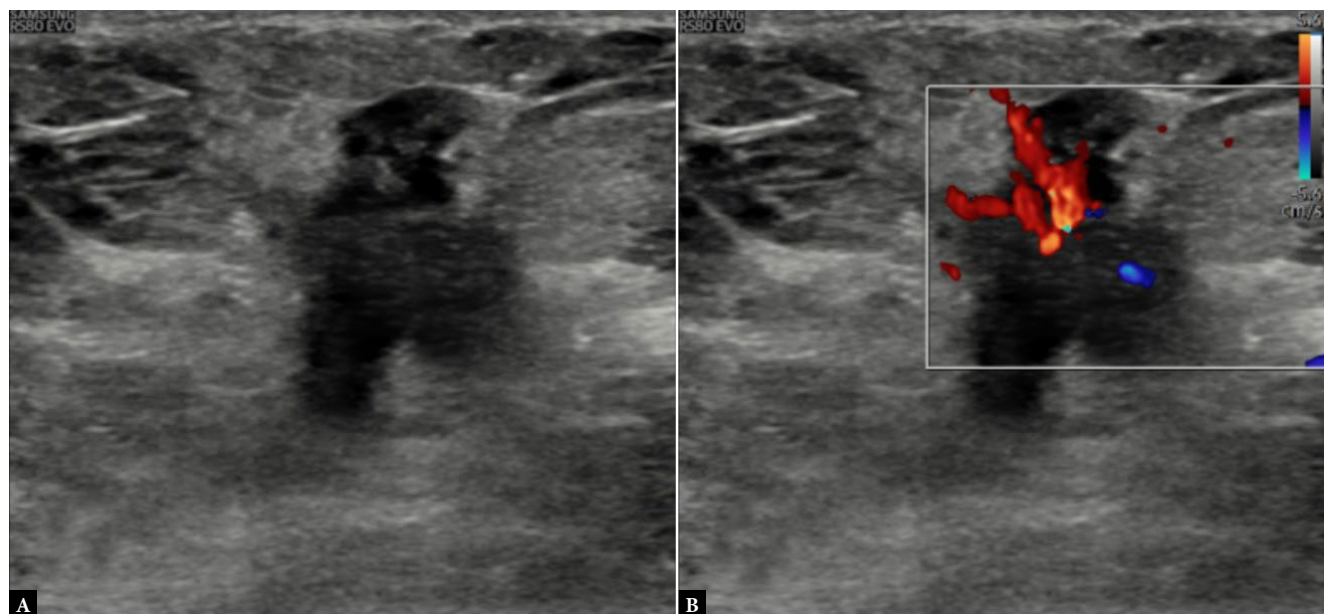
A 55-year-old female with invasive lobular carcinoma and luminal type B HER2-positive molecular subtype of breast cancer. Ultrasound image A. gray scale shows an irregular hypoechoic lesion, taller than wider, having spiculated and microlobulated margins, and posterior acoustic shadowing B. color Doppler shows internal vascularity
